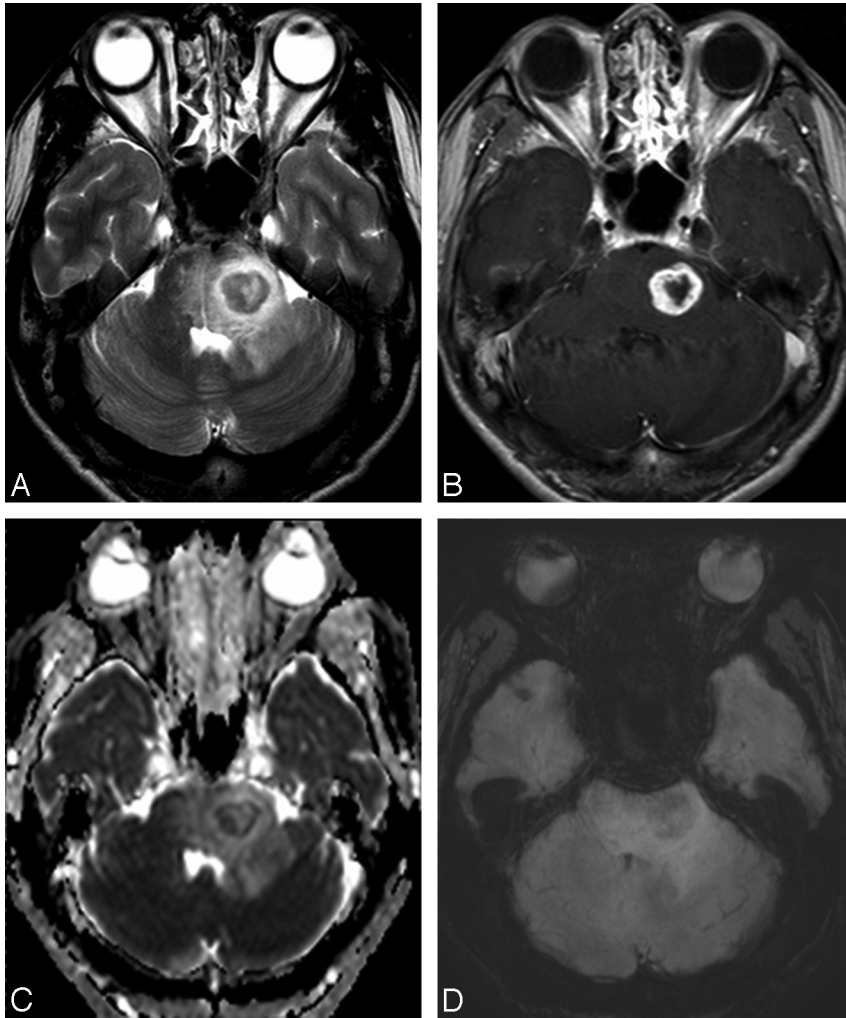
MR images of a 47-year-old man with a fungal granuloma. *A*, The axial T2-weighted image shows a mass with central necrosis and surrounding edema in the left pons. *B*, The contrast-enhanced axial T1-weighted image shows the mass with irregular peripheral rim enhancement. *C*, Apparent diffusion coefficient shows relatively restricted diffusion in the periphery of the mass. *D*, HR-SWI reveals fuzzy and diffuse low signals (not defined as ITSS in the present study) in the periphery of the mass.
